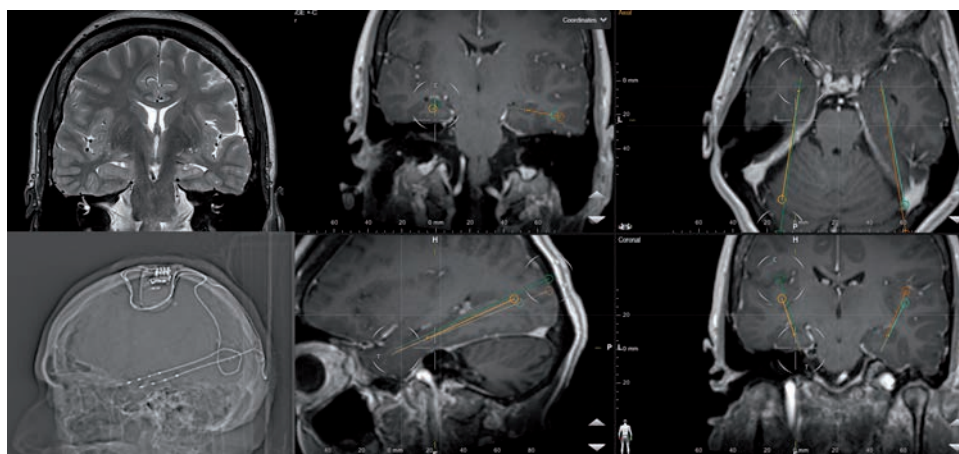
Demonstrative case of a RNS for bitemporal epilepsy. The patient had a history of bitemporal epilepsy. MRI demonstrated T2/FLAIR signal in the left hippocampus, consistent with mesial temporal sclerosis. Phase I evaluation was consistent with bitemporal epilepsy. They underwent bihippocampal RNS placement for treatment of epilepsy with reduction in seizure burden and frequency.
